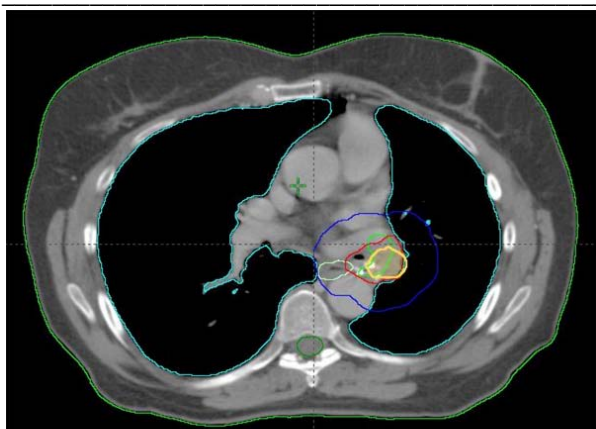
Rigid registration between pre-therapeutic PET/CT, pCT and rCT. Mediastinal window shows overlapping between SUVmax50 (Yellow line), recurrence (Green line). GTV and PTV are red and Blue.
